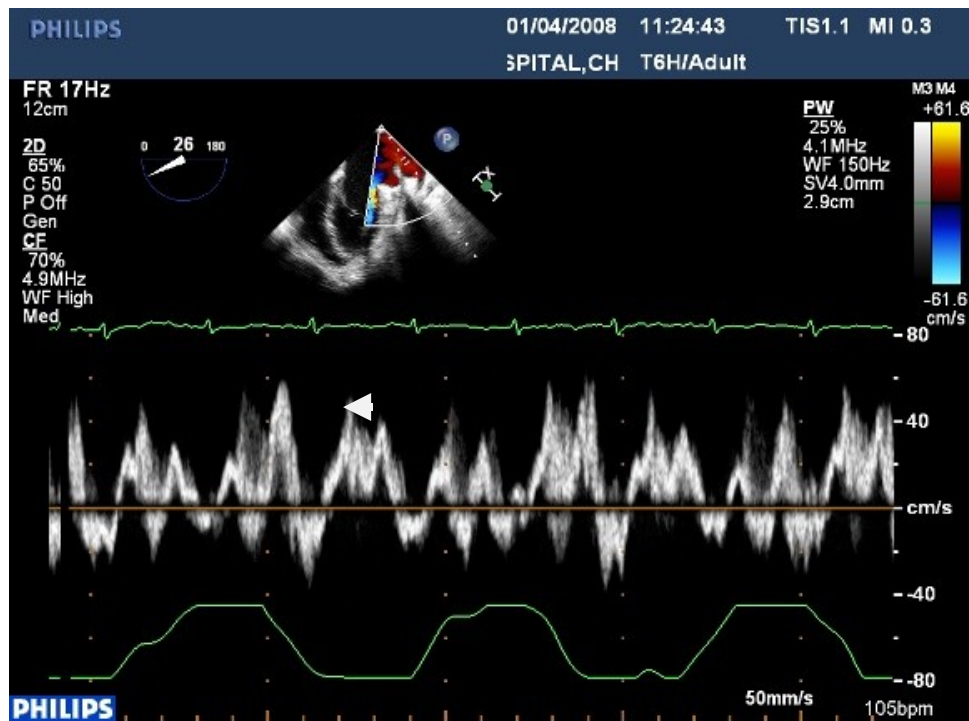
Pulmonary venous doppler-expiratory increase in diastolic (D) velocity
